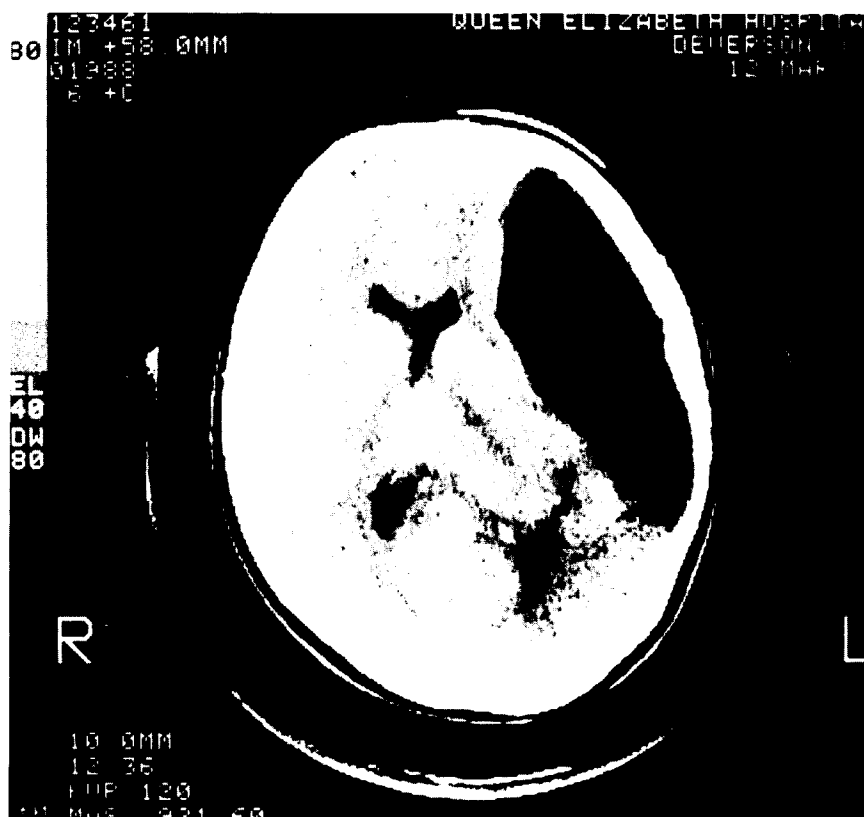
Essentially unchanged CT scan appearances 3 years later.
